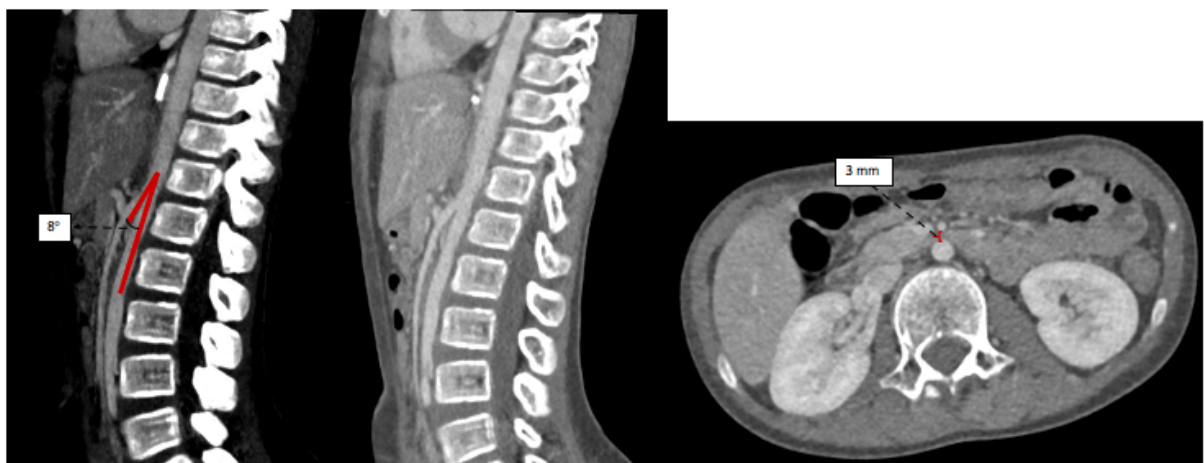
Contrast-enhanced CT of the Abdomen and Pelvis. Reduced aortomesenteric angle measures 8° and reduced aortomesenteric distance of 3 mm. Third part of the duodenum is compressed. Measurements along with fluoroscopic findings are suggestive of SMA syndrome.
